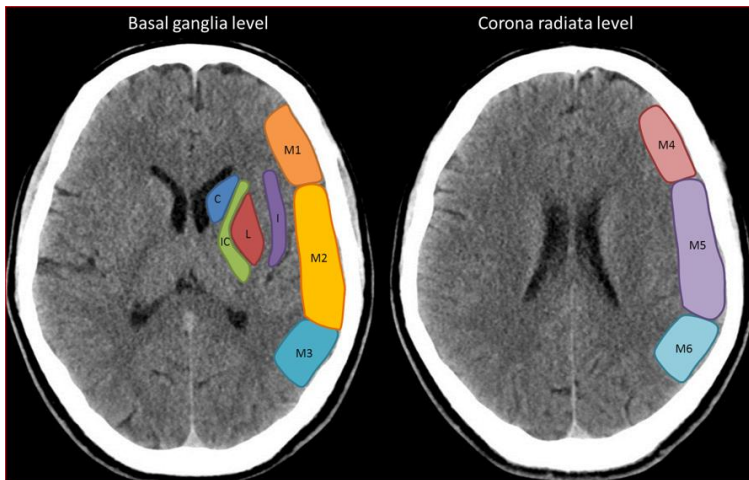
MCA-Alberta Stroke Program Early CT score (ASPECTS) by May 2022(80).
